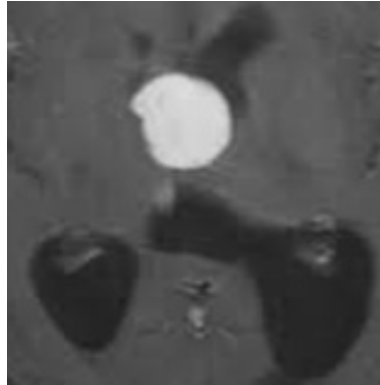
Image extracted from a brain tumor MRI scan
